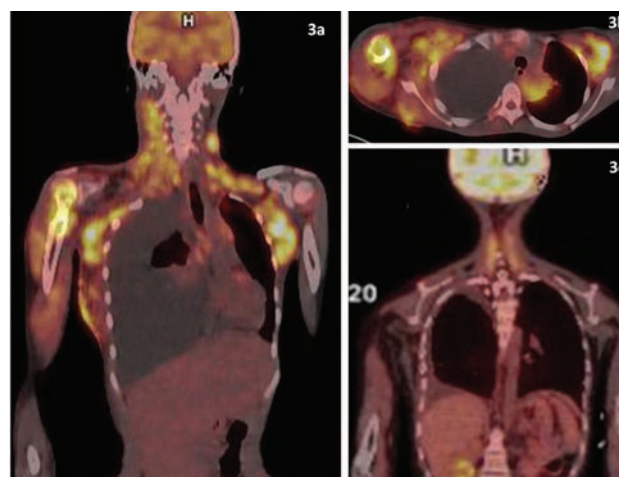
(A) Whole body positron emission tomography computed tomography scan. Pretreatment image showing metabolically active supradiaphragmatic lymphadenopathy with bone (right humerus), soft tissue (right chest wall), right pleural tissue deposits, and right pleural effusion. (B) Pretreatment cross-sectional image shows contiguous involvement. (C) Posttreatment image (after 4 cycles) reveals complete metabolic response.
